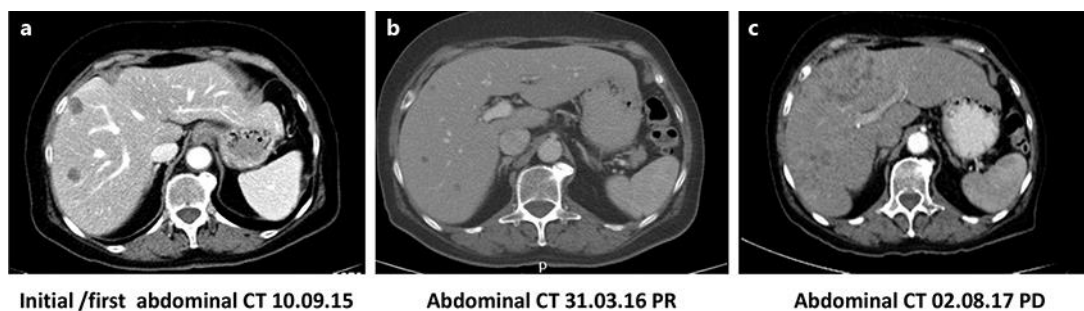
Abdominal CT images during trabectedin treatment. a Disease progression after pazopanib treatment. b Second diagnosis of partial remission after 6.5 months of trabectedin treatment (first partial remission observed after 3 months of trabectedin). c Disease progression after 22 months of trabectedin treatment. CT, computed tomography; PD, progressive disease; PR, partial remission.
